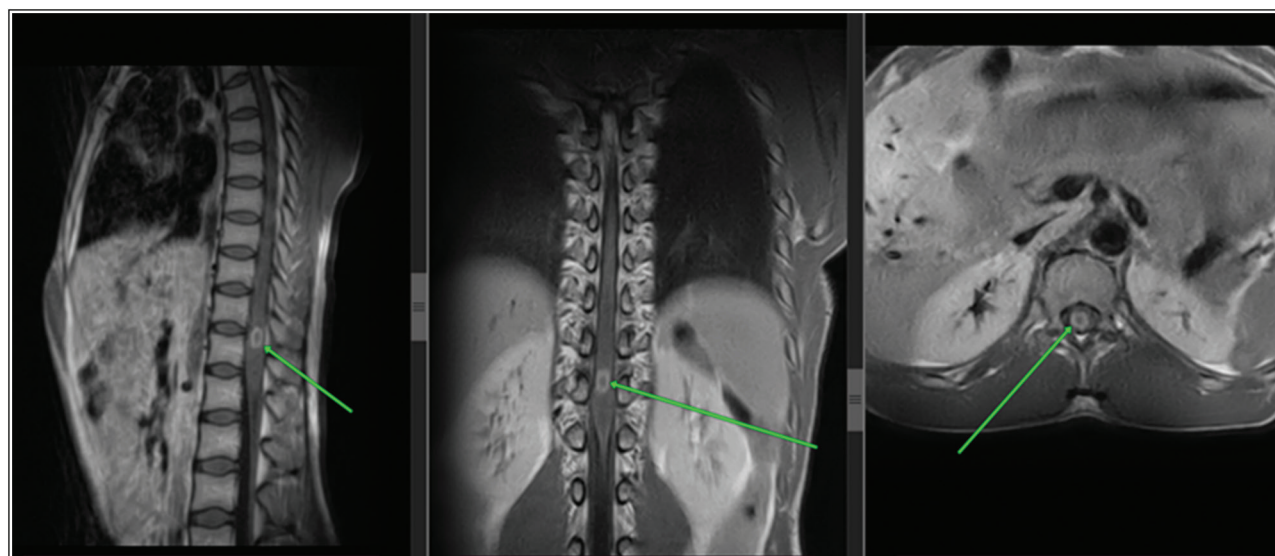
T1 gadolinium-enhanced magnetic resonance imaging of the thoracolumbar spine, showing a well define, ring enhancing, intramedullary mass straddle between T12 and L1 (green arrows)
